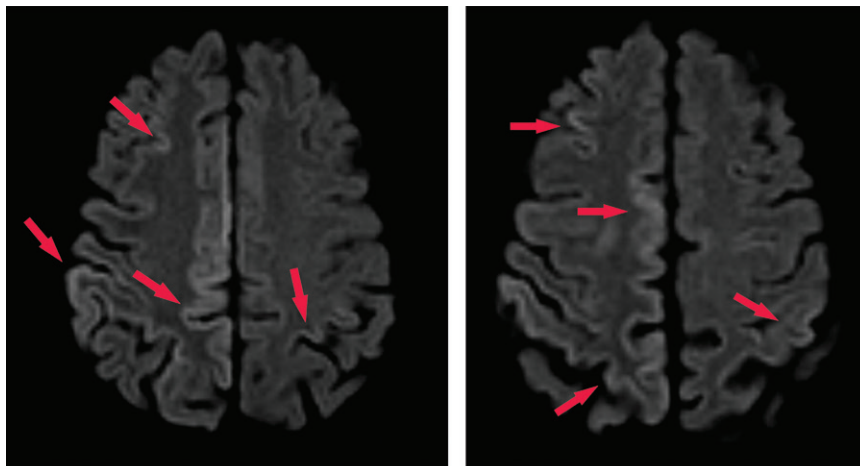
Creutzfeldt-Jakob disease. Axial diffusion-weighted MR images in a patient with rapidly progressive dementia show gyriform areas of hyperintensity of the cortical ribbon sign (arrows), a finding suspicious for Creutzfeldt-Jakob disease. The diagnosis was confirmed on the basis of clinical and imaging findings and elevated cerebrospinal fluid 14-3-3 protein levels.
